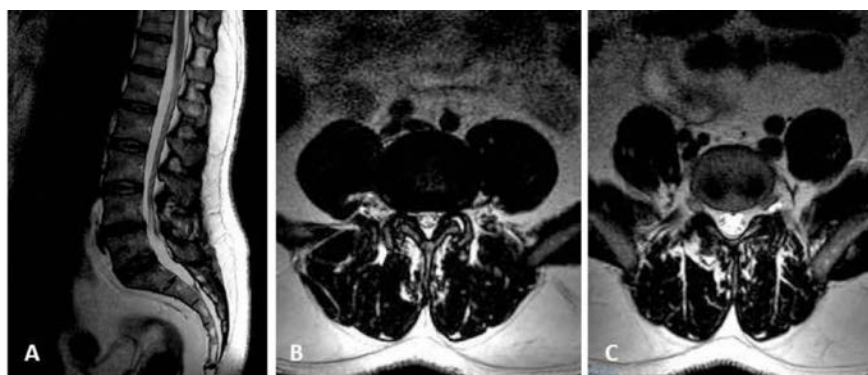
Sagittal magnetic resonance imaging (MRI) of the lumbar spine in T2 (A), transversal MRI of the lumbar spine in T2 showing a protrusion of the disc between L4 and 5 causing a slight spinal stenosis (B) and a moderate swelling of the right spinal nerve root L5 (C).
